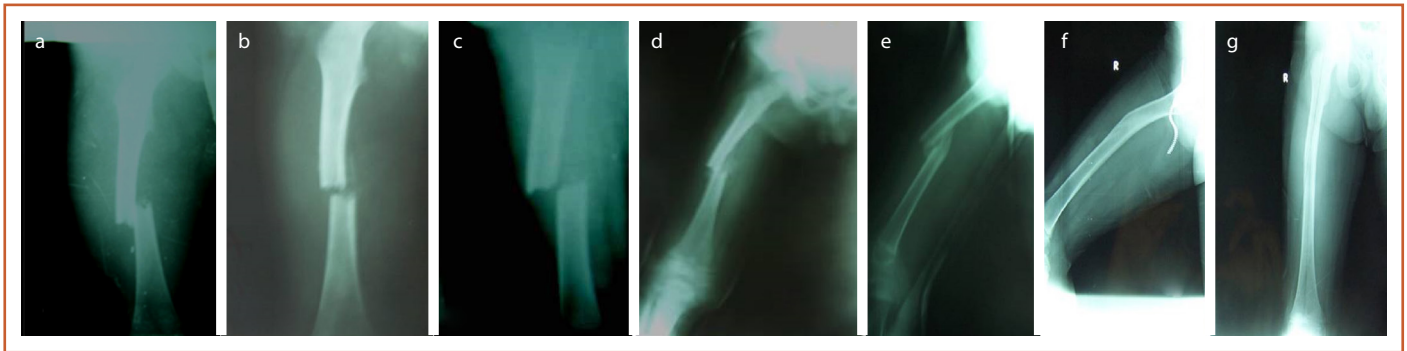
Five-year-old boy fall from high, (a) first AP x-ray, (b,c) 12. day in skeletal traction AP, Lat, (d,e) 26. day in spica cast AP angulation 167 degree, Lat 163 degree x-ray graph. (f,g) Four year later AP angulation 175 degree, Lat angulation 168 degree.
